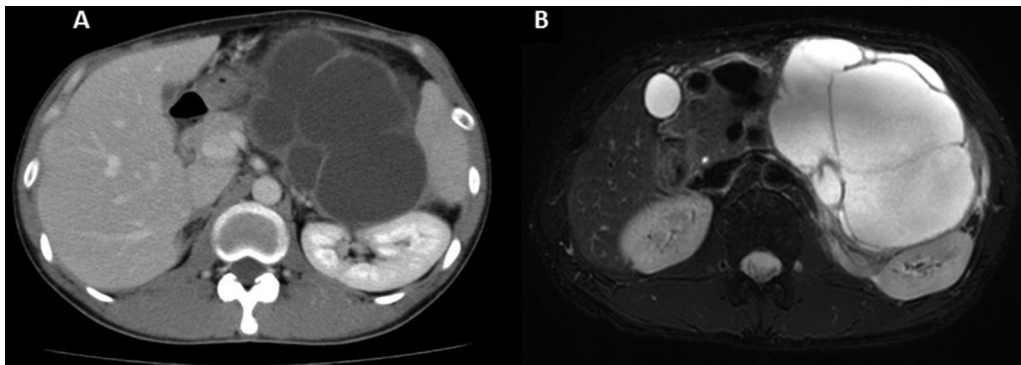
Abdominal computed tomography and magnetic resonance imaging of the present case. (A) Abdominal computed tomography showed a fluid-filled multilocular mass measuring 13.5 cm in diameter around the tail of the pancreas. (B) A T2-weighted magnetic resonance image showed a high signal-intensity tumor without a solid component.
